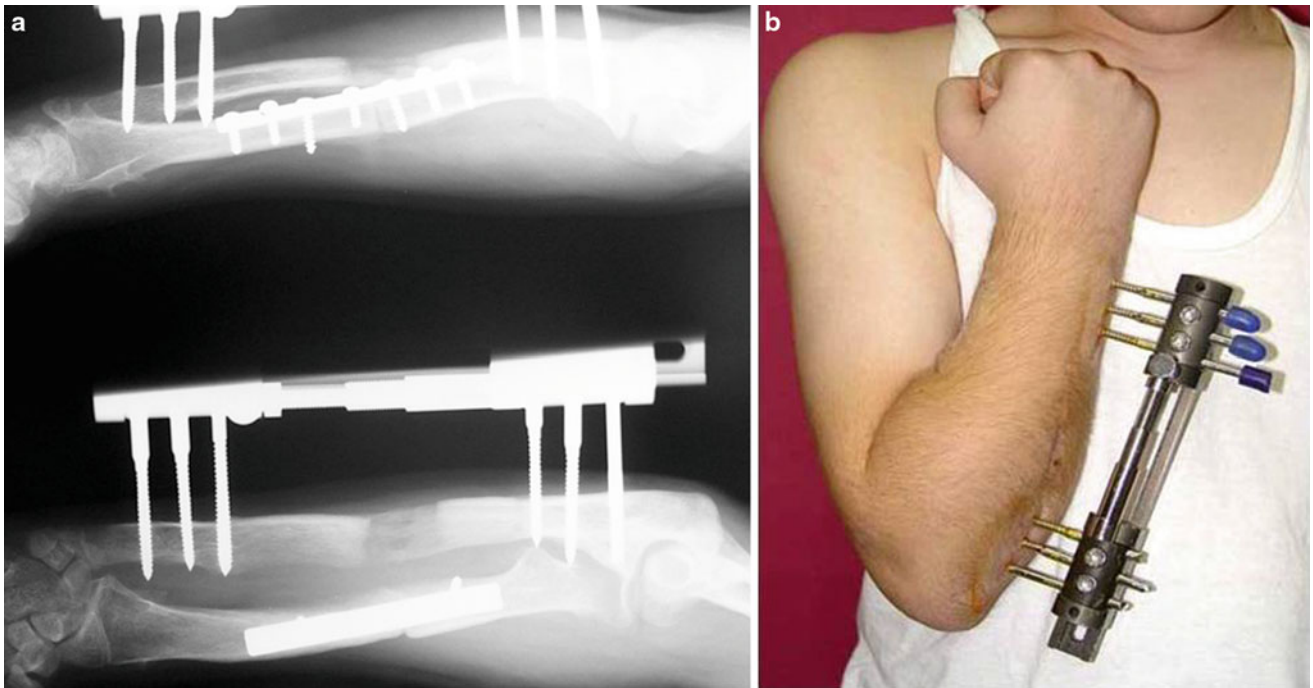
(a) X-ray at third month, during consolidation of the regenerate bone of the ulna. The radius osteotomy is also showing signs of bridging. (b) Clinical photo of the patient with full elbow flexion
